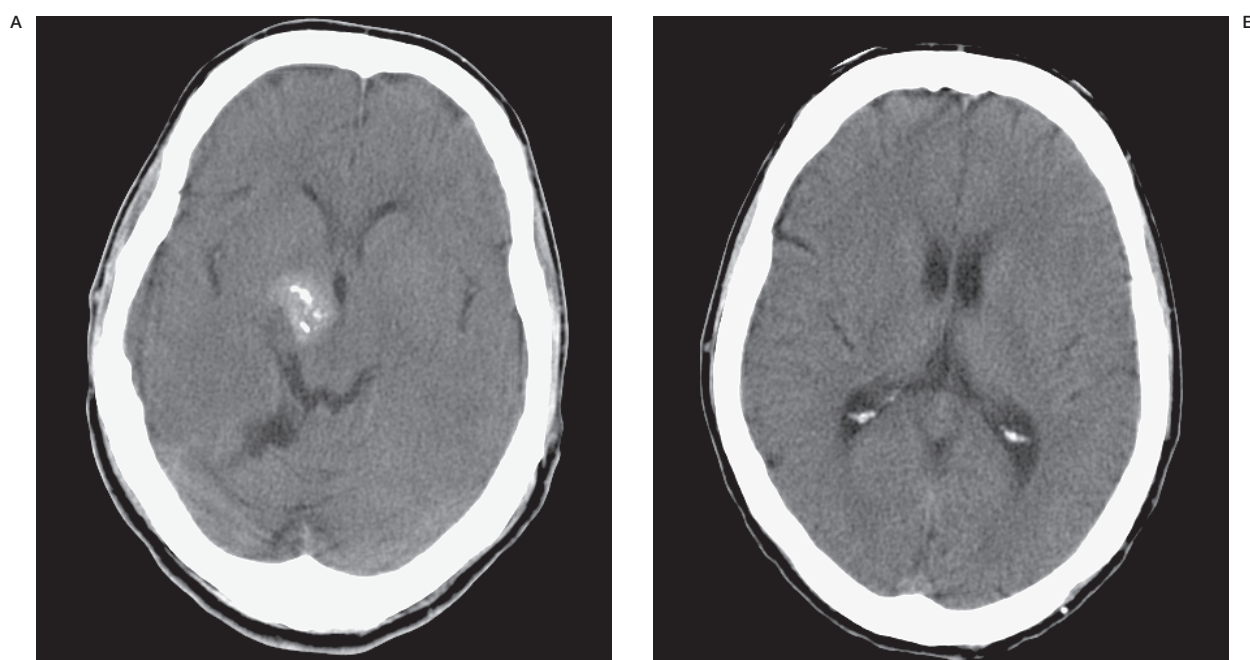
A,B) CT scan showing a calcified cavernoma in the right thalamus and mid-brain. No evidence of infarction in the right middle cerebral artery territory is seen at this stage.
